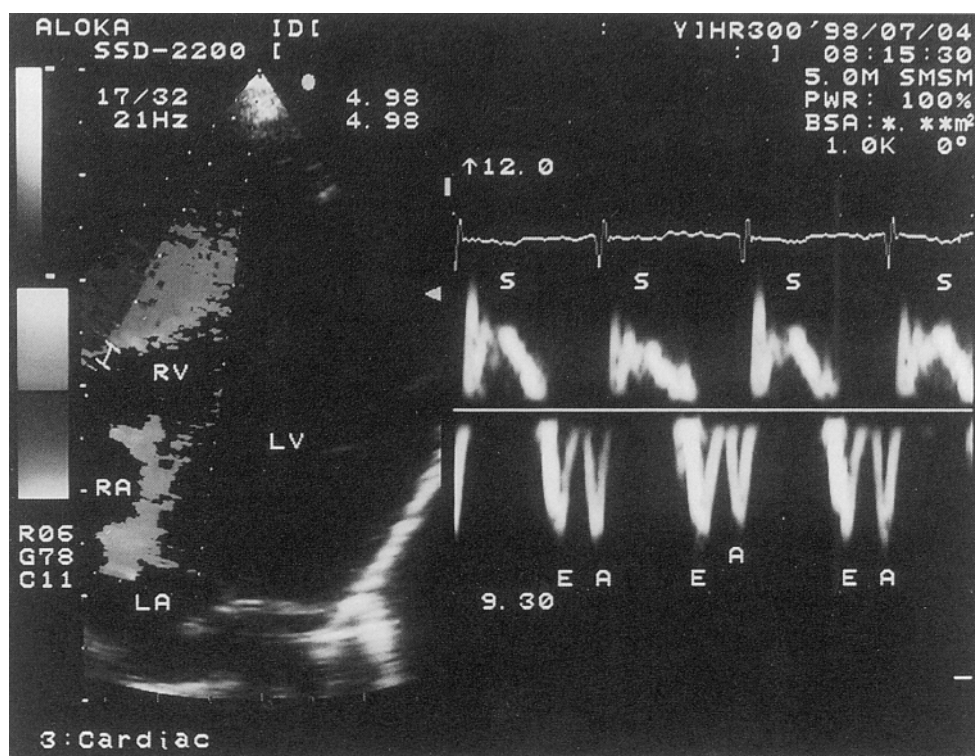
Sample recording of myocardial velocity by tissue Doppler imaging in the 4-chamber view of the right ventricle.
